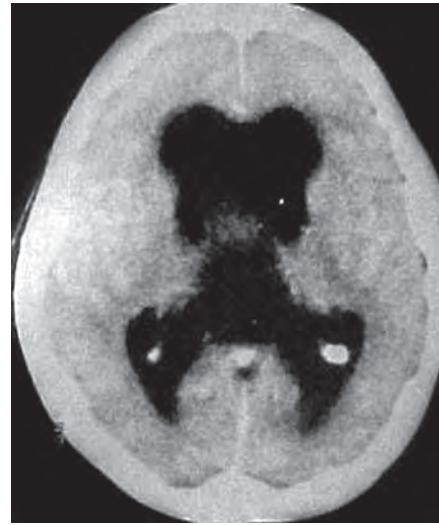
CT scan of the brain showing symmetrical dilatation of both the lateral ventricles secondary to the obstruction of foramen of Monro
